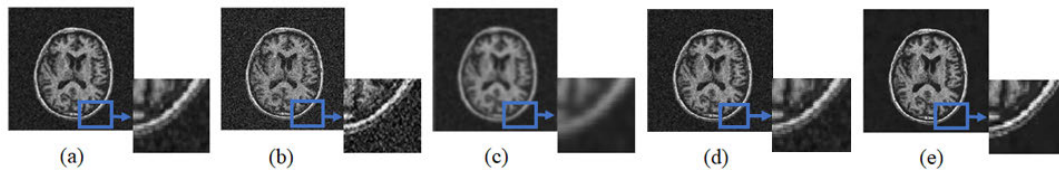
Denoising by different algorithms on real 3D MRI brain scans [46]: (a) TV [61], (b) NLM [59], (c) ADF [60], (d) RED-WGAN [37], and (e) Proposed 3D.
